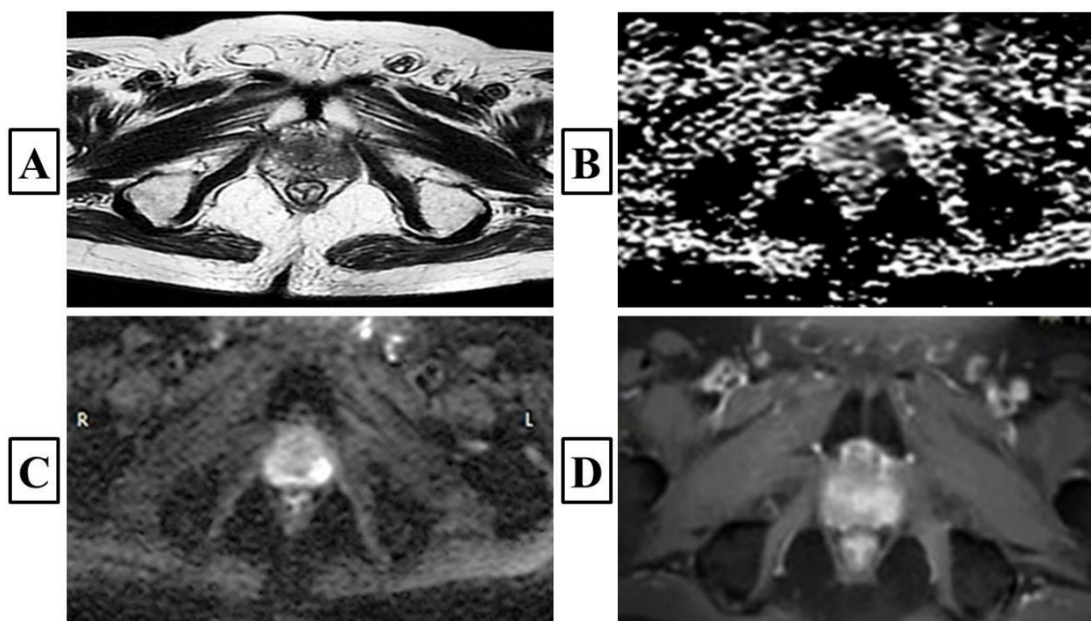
shows prostatic adenocarcinoma with Gleason score 4 + 4 in a 65- year-old male patient with serum PSA >30 ng/ml. (A) Axial T2WI shows circumscribed homogeneous moderate hypointense mass less than 1.5 cm seen involving the LT posterolateral peripheral zone of the prostate. (B) Axial ADC shows focal markedly hypo intense mass less than 1.5 cm. (C) Axial high b value DWI shows focal markedly hyper intense mass less than 1.5 cm (the final PI-RADS score on basis bpMRI was score 4). (D) Axial DCE shows +ve contrast enhancement. The final PI-RADS score based on mpMRI was score 4, DCE did not aid in the diagnosis of this case, and it was already diagnosed by bpMRI.
